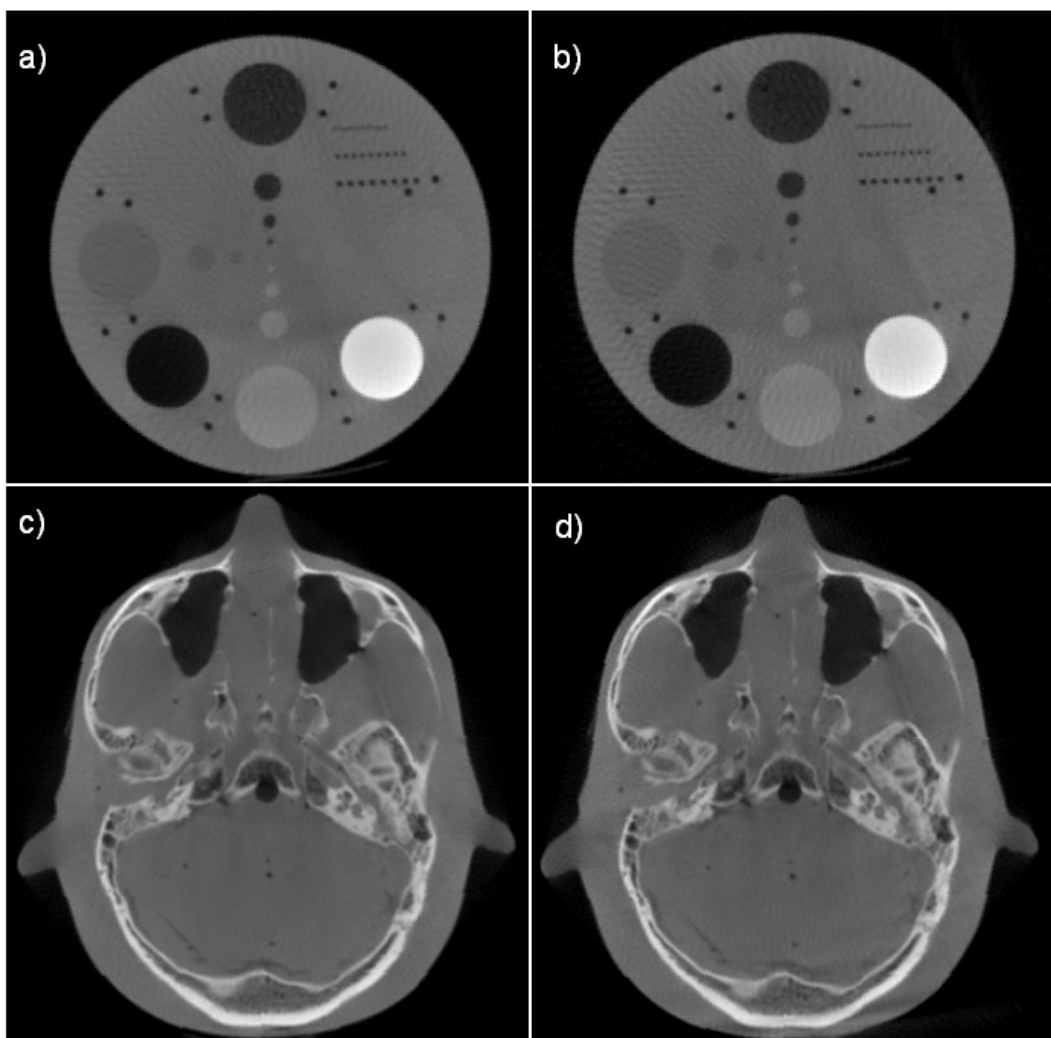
First CBCT reconstructions from the x-ray wagon
